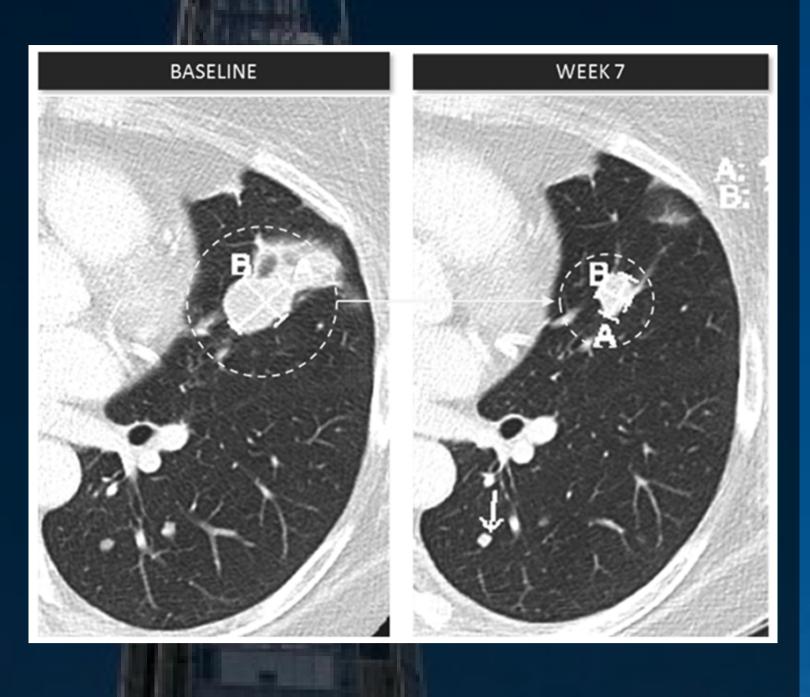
CT scans showing a 64% reduction in the size of a lung lesion in a patient with leiomyosarcoma who received injection of LTX-315 into a gluteal muscle lesion
